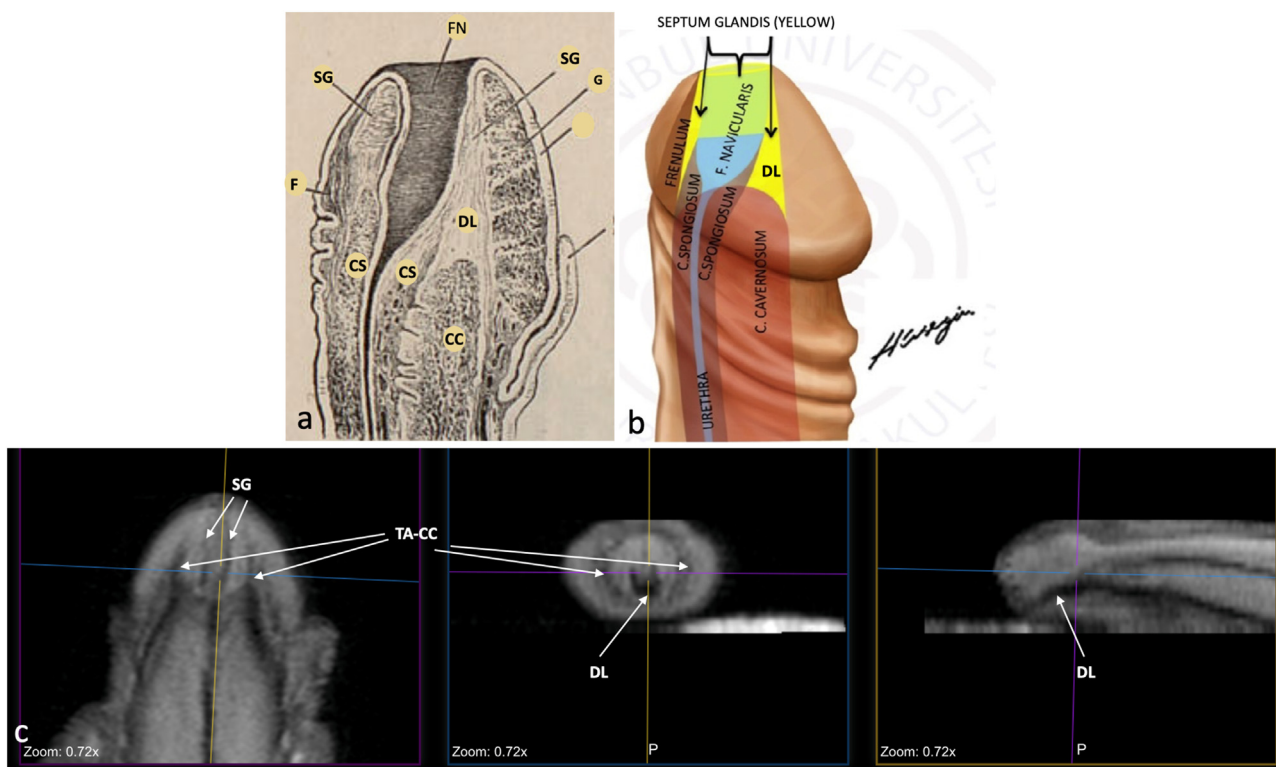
Anatomy of the glans penis showing how the corpus spongiosum gradually terminates at its junction with the navicular fossa. The glans is a separate tissue attached to the shaft of the penis by the extensions of the tunica albuginea of the corpora cavernosa and the tunica albuginea of the corpus spongiosum. These fibrous ligamentous tissues form the distal ligament, extend into the glans and divide the glans into outer and inner layers, cover the navicular fossa, and connect to the foreskin with septum glandis and frenulum (a and b). MRI views of the fibrous ligamentous tissues of the penis: transvers, coronal and saggital sections at the same level (c) [2,3]. SG:septum glandis, TA-CC:tunica albuginea of the corpora cavernosa, DL:distal ligament.
